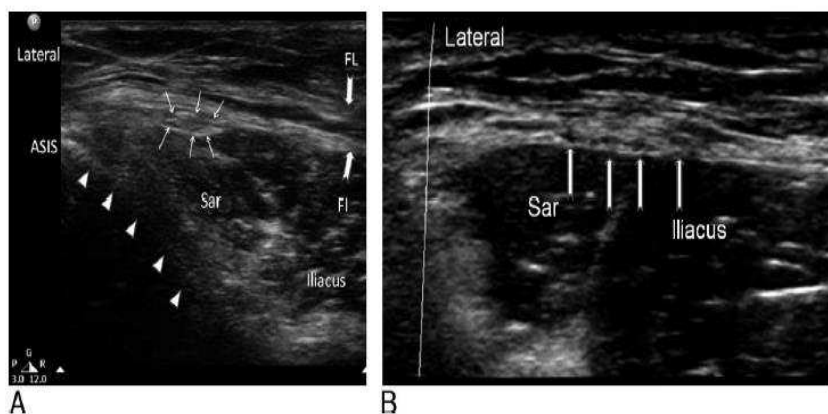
Ultrasonogram shows the lateral femoral cutaneous nerve (LFCN) (www.usra.ca). An LFCN is marked with a line arrow. The thick arrow marks the fascia (FL stands for fascia lata, and FI stands for iliac fascia). The solid arrow shows the ilium (Sar stands for sartorius muscle) B, LFCN has bifurcated into smaller nerves and is shown as a hypoechoic structure (solid arrow line)[9].
